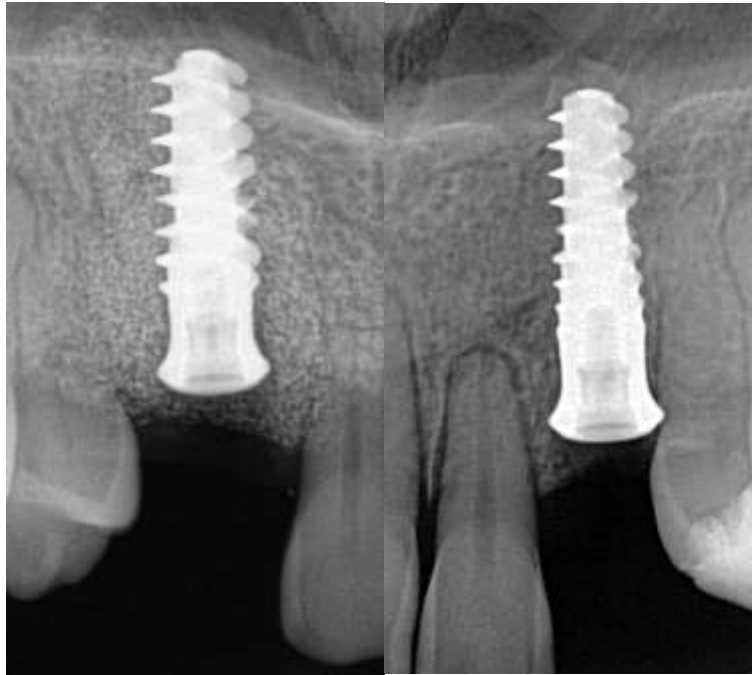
Periapical radiographs of Implant 13 (left), implant 23 (right)
